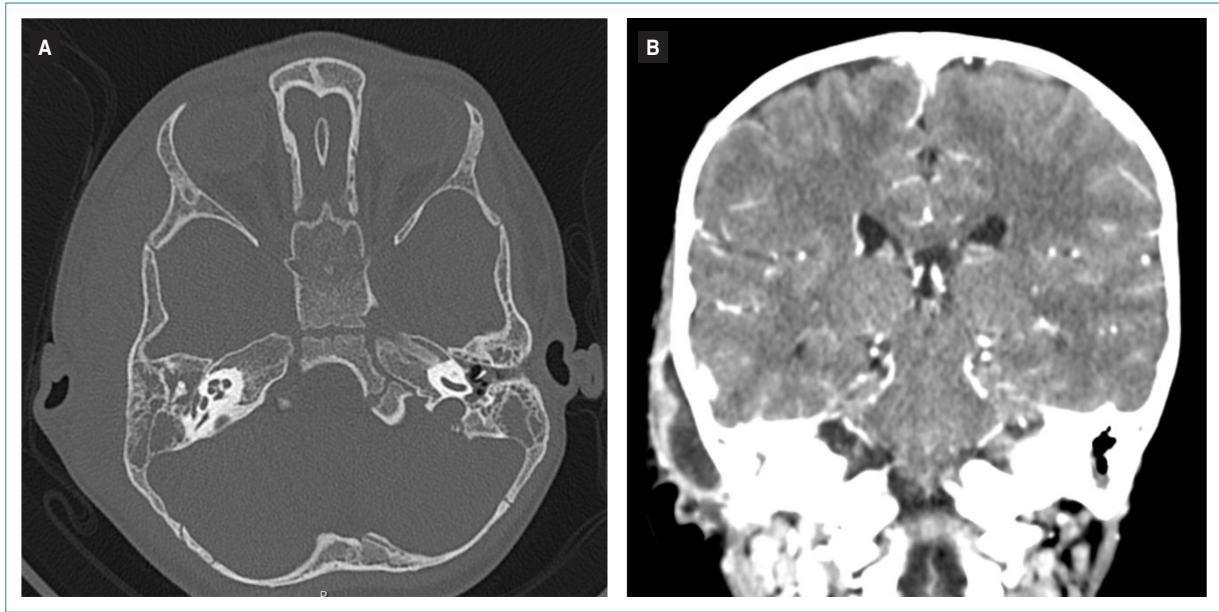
CT scans. Case 1 — Axial CT image shows bilateral mastoid opacification with marked swelling of the right zygomatic and temporal regions (A). The coronal CT image with contrast demonstrates a collection beneath the temporal muscle, just above the pinna (B).
